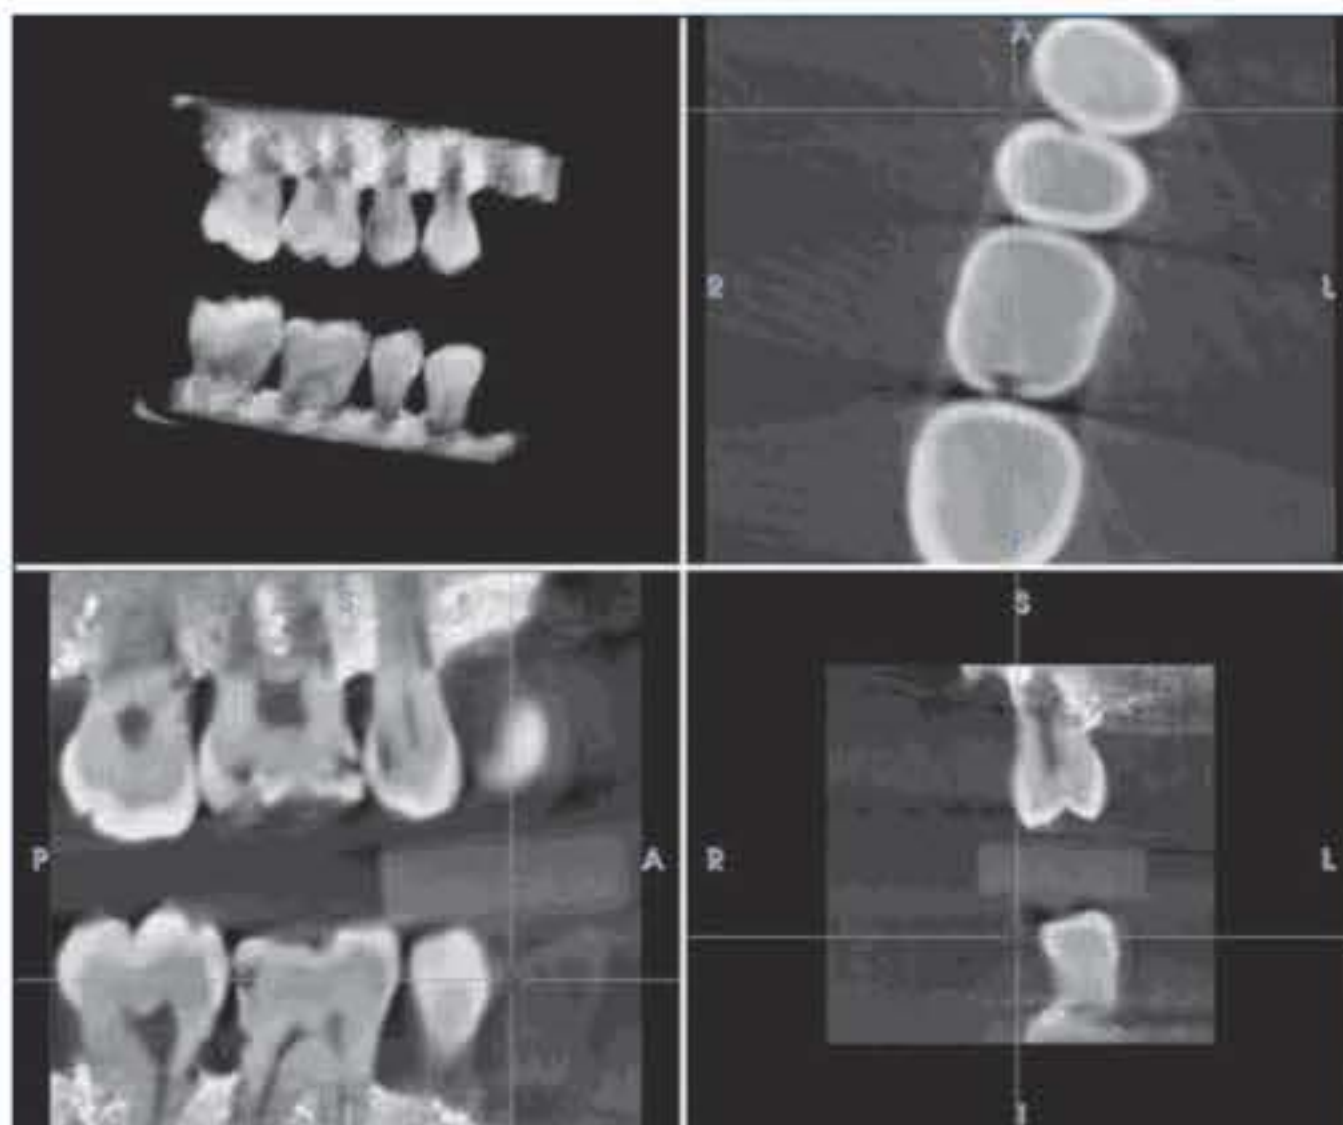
The status of the distal approximal surface of tooth 46 can also be clearly diagnosed with CBVI, enabling a therapy to be chosen with greater confidence than on the basis of conventional bitewing radiography. In addition, a significant dentin lesion is apparent in the maxilla at tooth 16, which could only be suspected from conventional imaging techniques and would most likely be overlooked.
